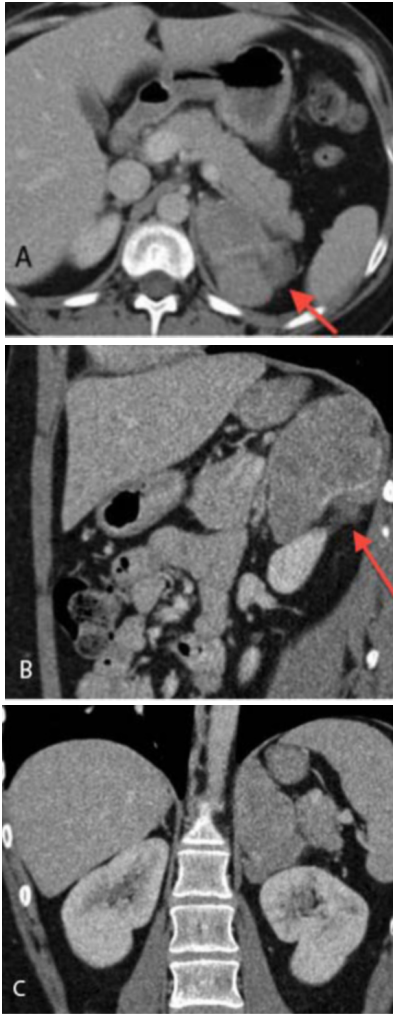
20-year-old female with Cushing's syndrome. Abdominal CT images were obtained in the axial (A), sagittal (B), and coronal (C) planes, 75 seconds after the administration of IV contrast. A heterogeneously enhancing mass measuring 8x4.5x7cm arose from the left adrenal gland. Portions of the mass had ill-defined borders, and there was suggestion of invasion into the retroperitoneal fat at the posterior margin of the lesion (arrow). There was no evidence for invasion of the adjacent pancreas or kidney.
